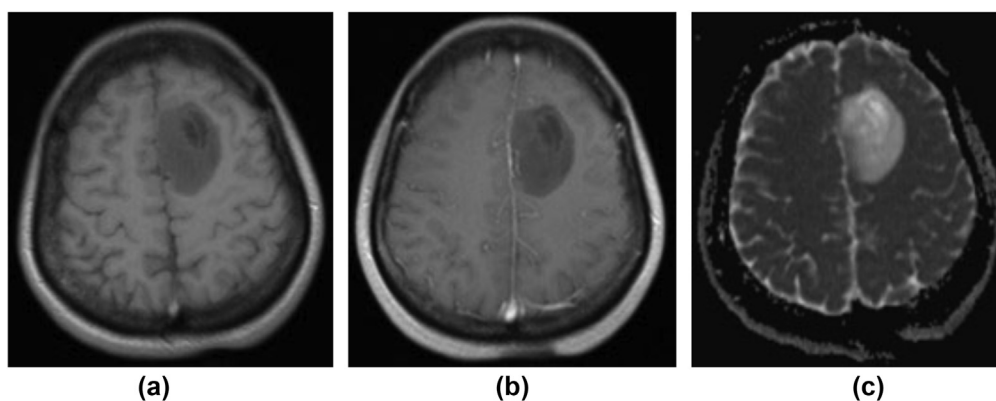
A 39-year-old woman with left frontal anaplastic astrocytoma. (a) axial T1-weighted image shows an well-defined heterogenous mass with slightly low signal intensity. (b) post-contrast axial T1-weighted image shows no obvious contrast enhancement (Proportion non-enhancing=6); (c) axial ADC map shows that there is no obvious restricted diffusion (ADC-Entropy=5.575).
